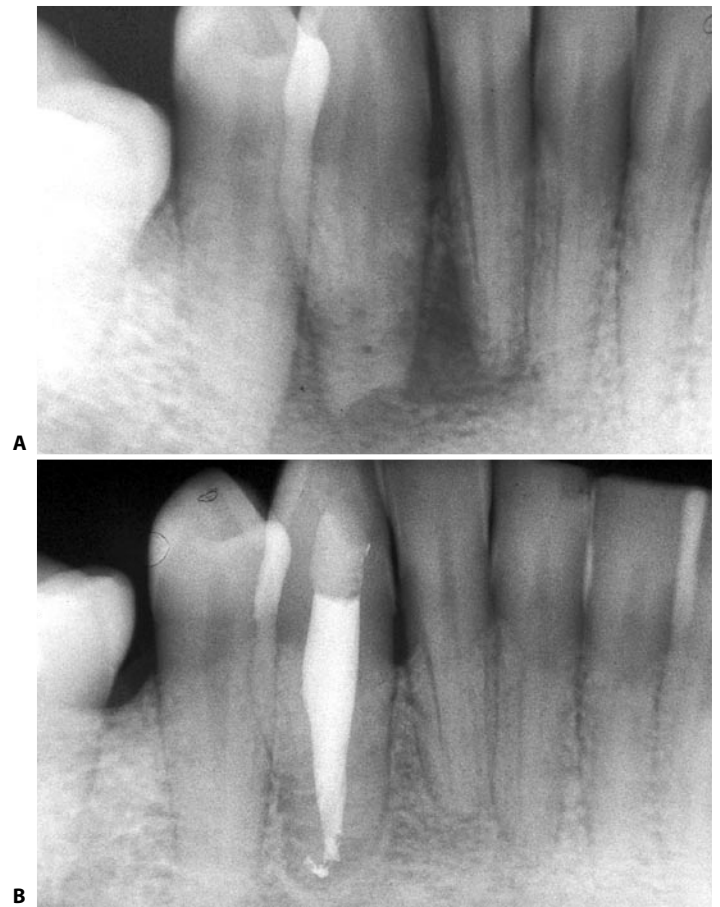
A. The preoperative radiograph shows a lesion that involves two apices, but only one of the two affected teeth has a necrotic pulp. B. Twenty-seven months later.
